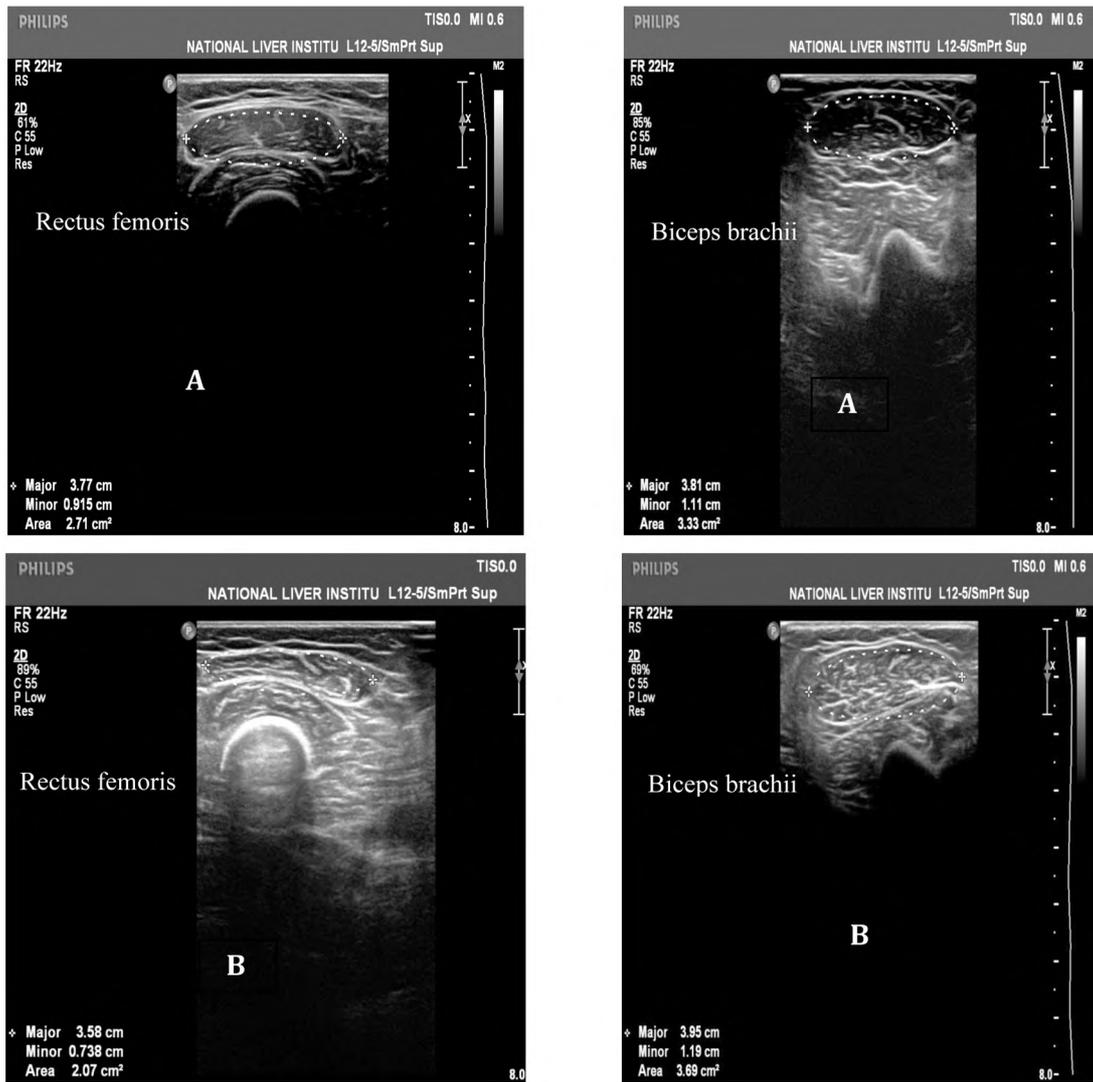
Pictures of Ultrasonic cross-sectional area (ellipse mark) showing different echogenicity between healthy (A) and diseased muscles (B).
